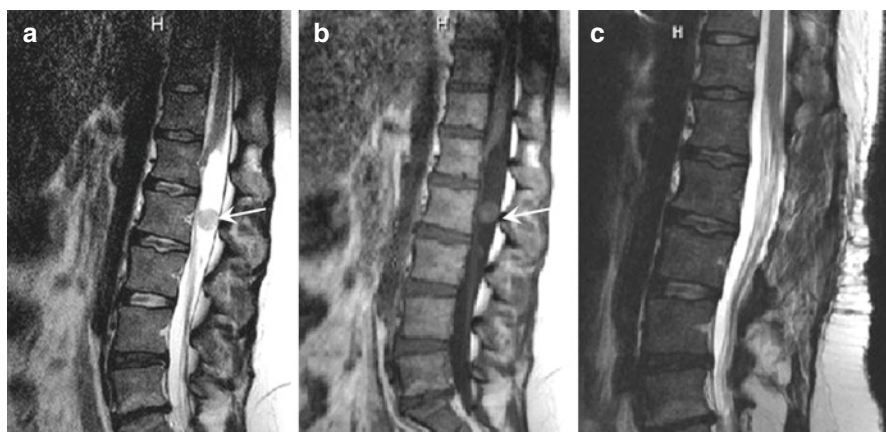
Imaging of a 35-year-old patient with severe low back pain and urinary retention (patient operated on by the senior author [KIA]). (a) Preoperative sagittal T2-weighted MRI of the lumbar spine. (b) Sagittal post-contrast T1-weighted MRI of the lumbar spine demonstrating MPE at L2 with large cystic component, involvement of conus and lumbar intumescence, and hydromyelia (type IVB). (c) Postoperative sagittal T2-weighted MRI of the lumbar spine demonstrating complete resection with cyst drainage and resolved hydromyelia. Urinary retention resolved completely, the patient had no neurological deficits
